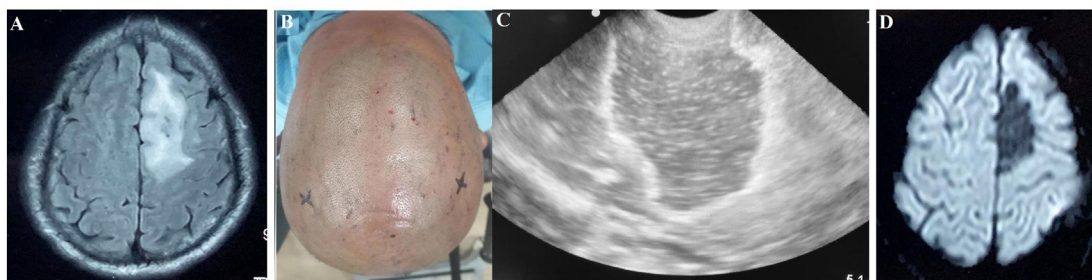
A: pre operative MRI (FLAIR) showing hyper intense lesion suggestive of LGG close to the motor cortex. B: Pre operative patient image showing the marked area for hand as stimulated through TMS. Note the marked area on left side is slightly posterior to right one. C: Intra operative 2DUSG showing tumor margin demarcated by water saline mixture. D: Post op MRI (FLAIR) showing resection of the tumor.
